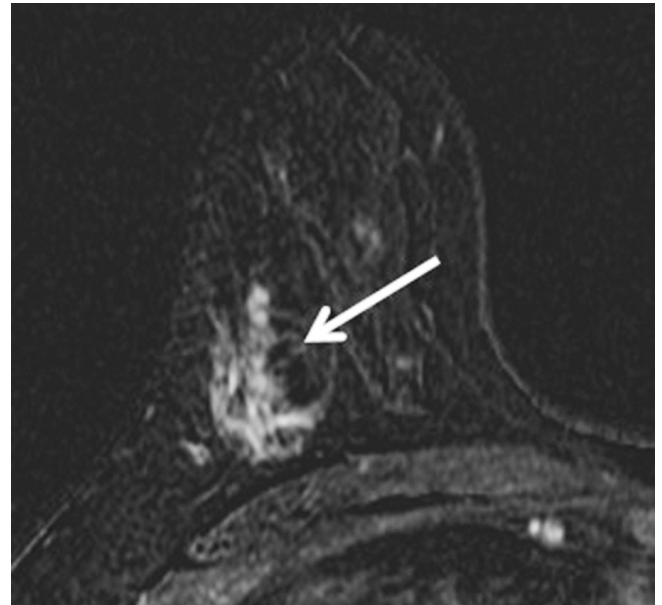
48 year-old female with invasive lobular carcinoma at right upper outer breast. Preoperative axial early contrast-enhanced T1-weighted subtraction MR image show suspicious non-mass enhancement at right upper outer breast (arrow). At breast-conserving surgery, positive resection margin was confirmed by intraoperative frozen sectional analysis and additional local excision was performed immediately.
